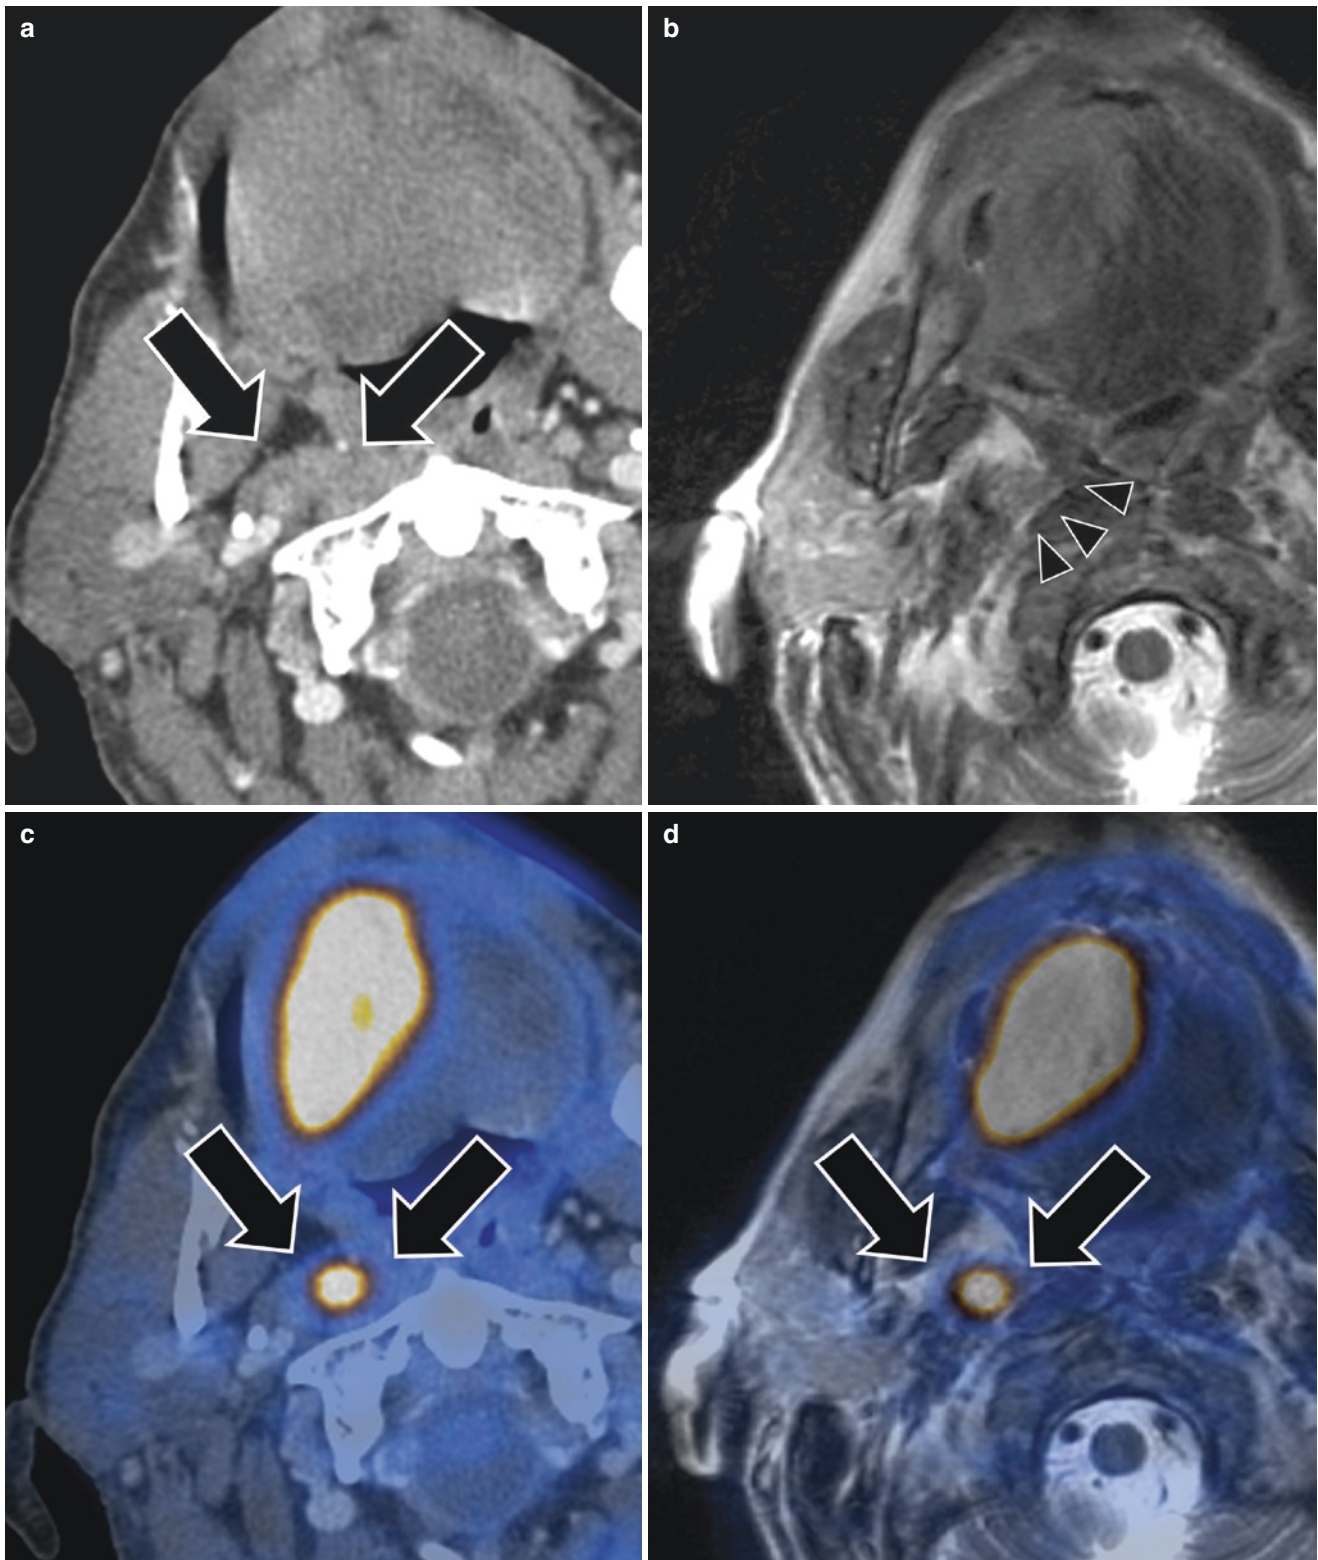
The lymph node metastases adjacent to the prevertebral muscle were clearly depicted on PET/CT (c, *thick arrows*) and PET/MR (d, *thick arrows*). On contrast-enhanced CT, it was difficult to completely rule out prevertebral muscle infiltration (a, *thick arrows*), which eliminated the option of surgical resection. Fat was detected between the tumor and prevertebral fascia on T2WI (b, *arrow heads*). This finding had high negative predictive value for evaluation of prevertebral space involvement on MRI. High intensity on echo-planar imaging
